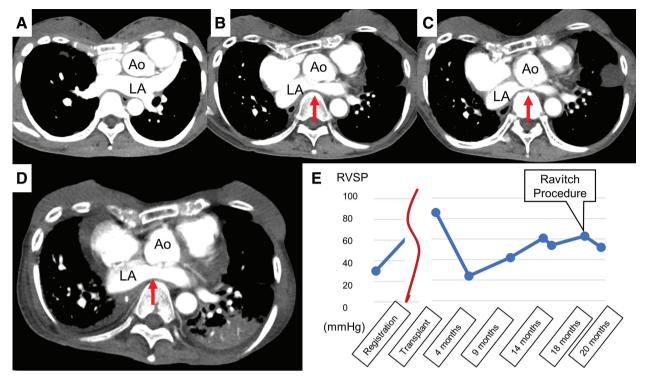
Mediastinal shift and associated change in RVSP. (A) Chest CT before transplantation showed that the patient had a flat chest and the mediastinum was deviated to the left. (B) Chest CT 5 months after transplantation showed that the transplanted left lung was well-inflated, resulting in a mediastinal shift to the right. The flat chest caused deformation of the left atrium, which narrowed the outflow tract of the pulmonary vein (red arrow). (C) Chest CT 14 months after transplantation. Progression of the mediastinal shift and flattened chest wall resulted in obstruction of the outflow tract of the pulmonary vein (red arrow). (C) Chest CT 14 months after transplantation. Progression of the mediastinal shift and flattened chest wall resulted in obstruction of the outflow tract of the pulmonary vein (red arrow). (E) The initially low RVSP was increasing by the time of transplantation. After lung transplantation, the RVSP decreased to almost the normal range. However, it gradually increased again in association with symptoms of right heart failure. After the Ravitch procedure, the RVSP decreased slightly. Ao: aortic arch; CT: computed tomography; LA: left atrium; RVSP: right ventricular systolic pressure
